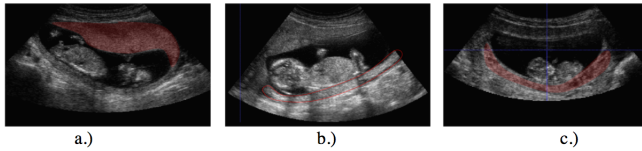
Ultrasound images of the placenta (highlighted/outlined in red) a.) a large placenta b.) a placenta effected by fetal shadowing c.) a small placenta
